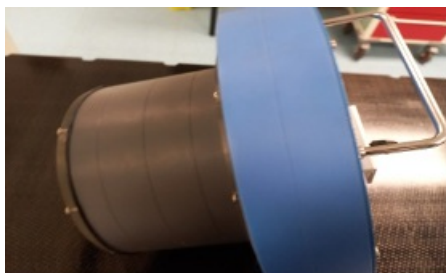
Set up of CT image quality measurement
